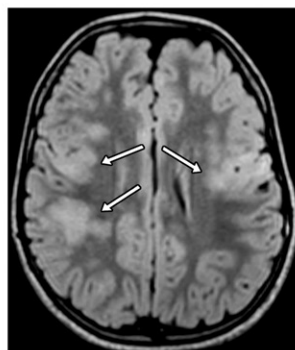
Extensive brainstem and brain involvement with myelitis, MOG antibody–seropositive, in a 6-year-old girl with headaches, unsteady gait, and impaired consciousness and a 7-day history of upper respiratory tract infection. (a–d) Sagittal (a) and axial (b–d) FLAIR images at onset show confluent signal intensity changes in the pons (arrow in a), prominent involvement of the left thalamus (arrow in b), and confluent diffuse areas of hyperintensity involving the cortex and subcortical white matter (arrows in c). Note the bilateral cortical lesions in the frontal lobes aside the cerebral falx (arrow in d). (e, f) Axial FLAIR images show expansion of the lesions (arrows) with new lesions in the right temporal and occipital lobes (not shown). (g) Diffusion-weighted image on day 8 after presentation (patient still symptomatic) shows areas of restricted diffusion (arrowheads) suggestive of cytotoxic edema. (h) Sagittal T2-weighted image shows hyperintensity in the thoracic cord (oval) extending almost three vertebral segments. (i) Axial T2-weighted image shows an H sign (arrowhead), indicating that the hyperintensity is confined to the gray matter.
